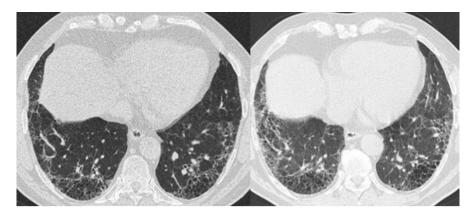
CT in the time of diagnosis and 5 years after the diagnosis with the progression of fibrotic changes
